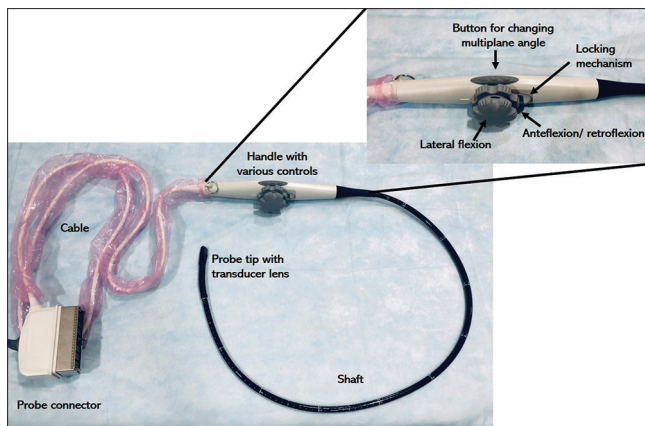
Different parts of a transesophageal echocardiography probe
